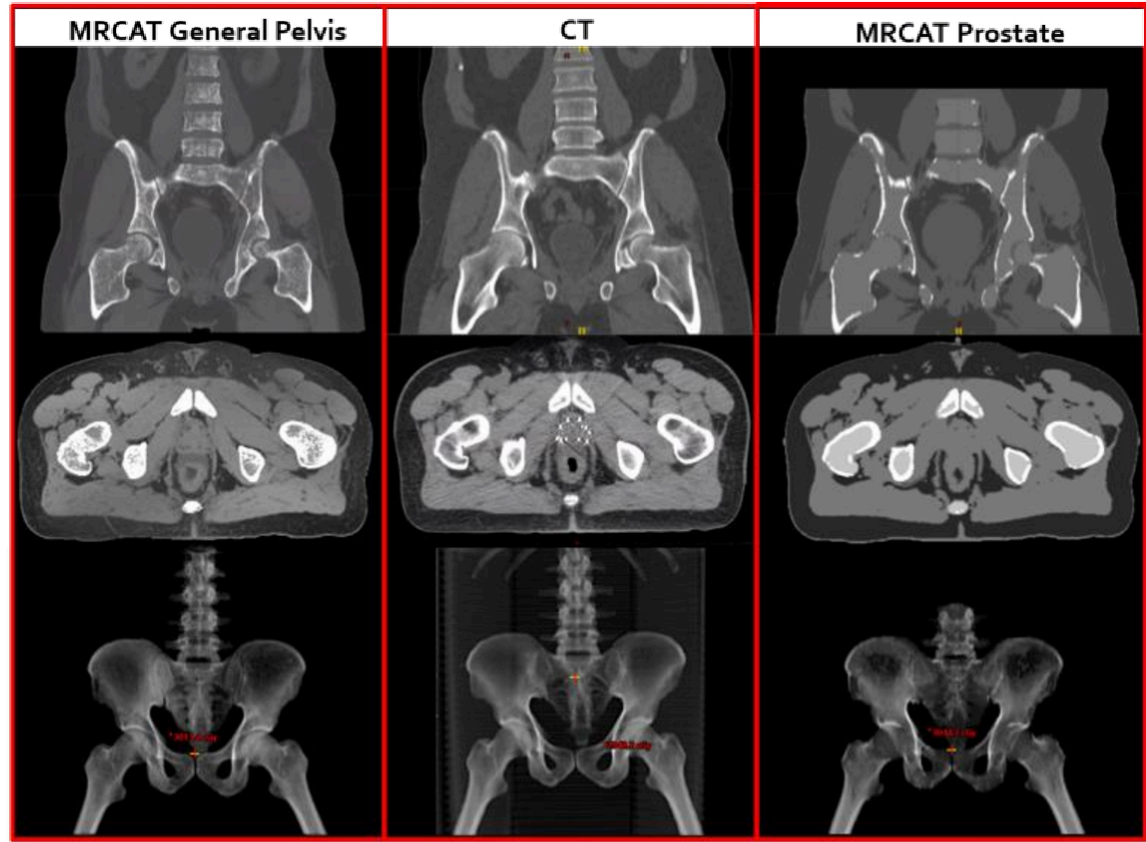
Comparison between CT and MRCAT General Pelvis and MRCAT Prostate synthetic CTs, and all associated DRRs
